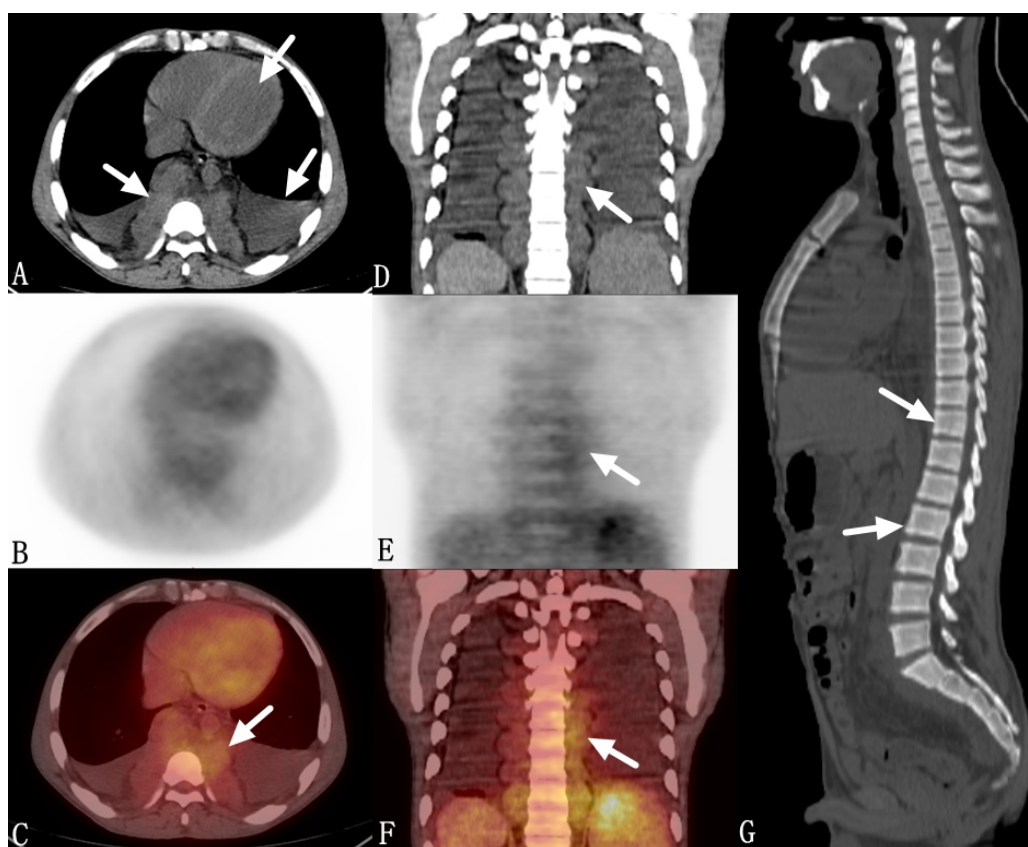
Axial and coronal PET/CT images revealed multiple, segmentally distributed paraspinal (T2-T11) soft-tissue nodules and masses exhibiting a clumped and beaded morphology. Some lesions showed fusion with ill-defined borders and mild ^{18}F -FDG uptake (SUVmax 1.64) (A-C, D-F, arrows). The CT component demonstrated diffusely increased bone density throughout the skeleton, with blurred trabeculae or a ground-glass opacity pattern (G, arrows).
